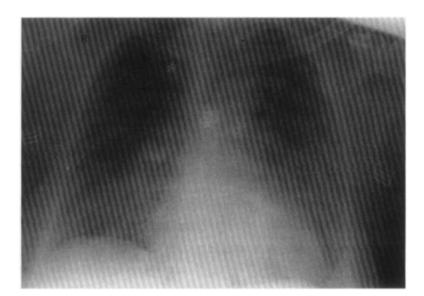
Chest x-ray film made with portable technique. There is evidence of pulmonary edema as well as a suggestion of tracheal deviation to the left (arrow).
